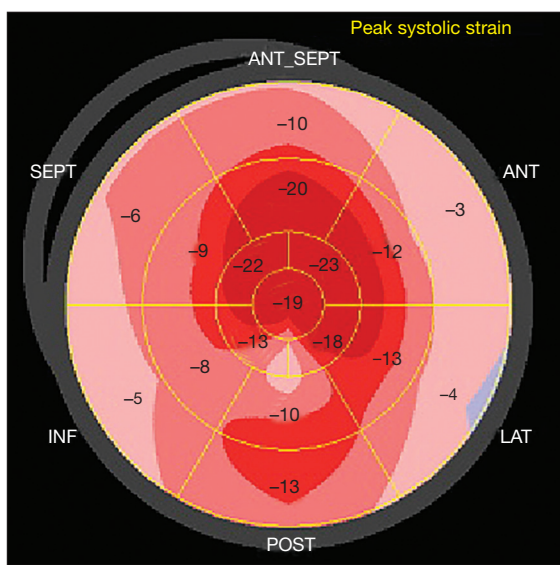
Longitudinal echocardiography strain depicted in bull's-eye map showing preserved apical strain with reduction of mid and basal strain that results in hallmark “cherry on the top” pattern, a characteristic strain finding for cardiac amyloidosis.
